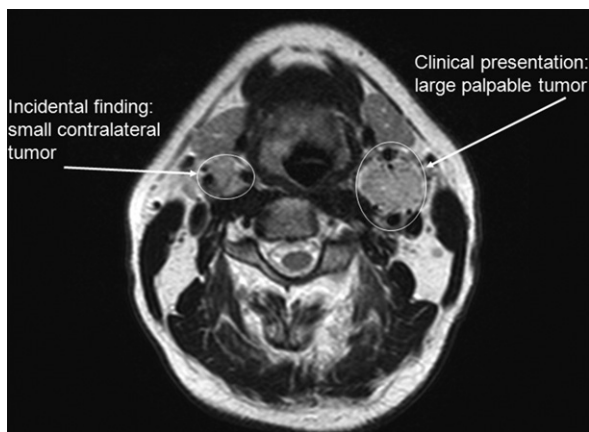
online only. Magnetic resonance imaging scan of a patient with bilateral carotid body tumors.
